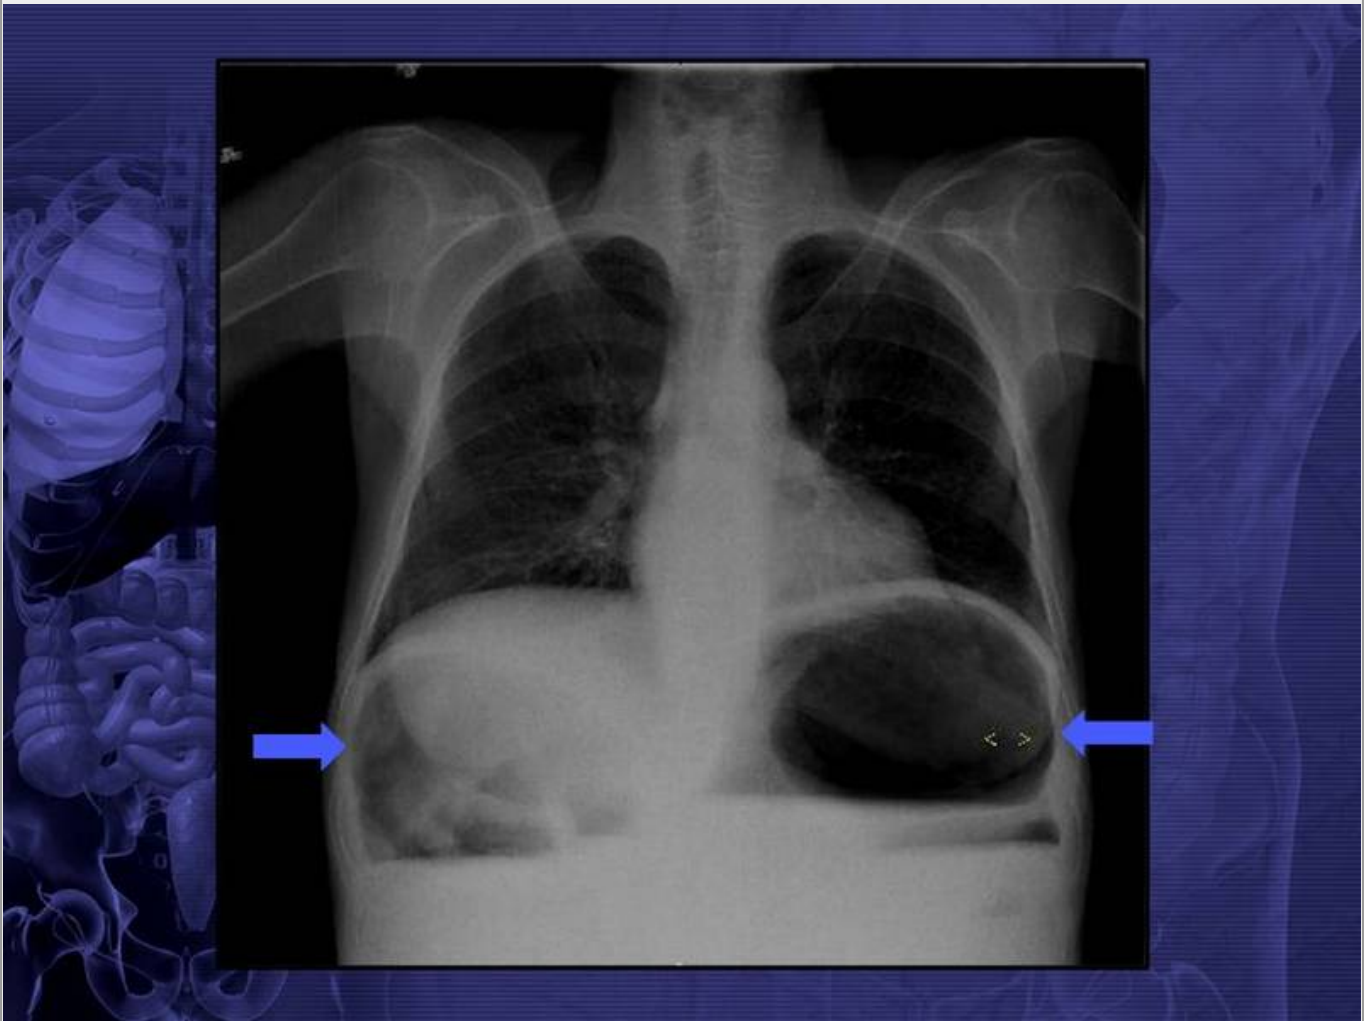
Chest frontal radiograph of a patient with scleroderma shows marked dilatation of the hepatic and splenic flexures of the colon.
